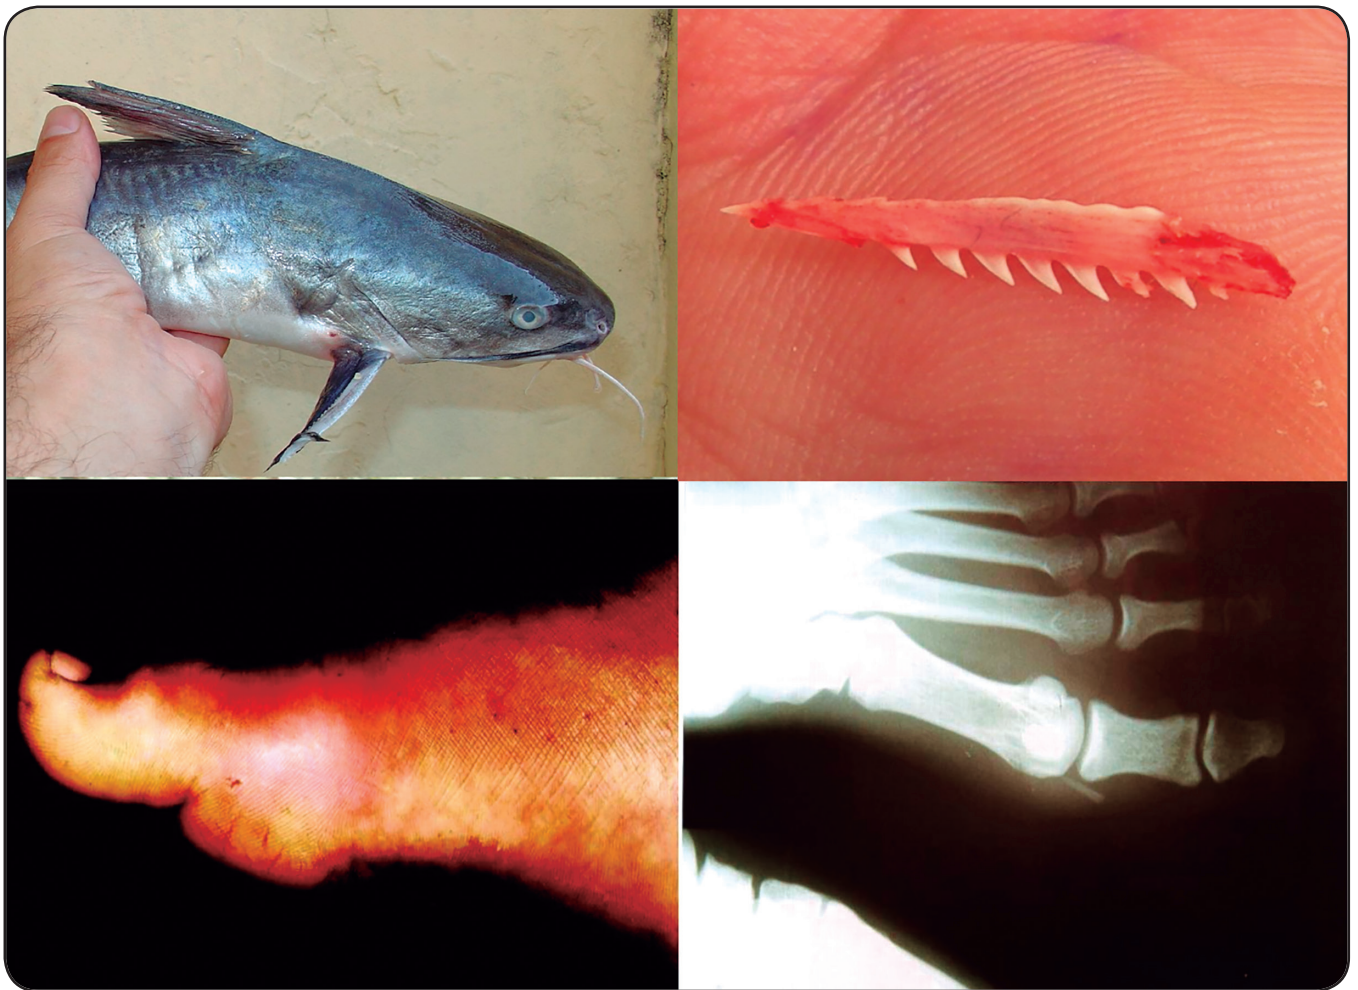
Marine catfish (Top left). Pectoral Sting in detail (Top right). Persisting inflammation three days after an injury caused by a catfish (Bottom left). Conventional radiography of the injured left foot (Bottom right). Increased radiographic density is seen around the first metatarsophalangeal joint (soft-tissue swelling). Note the sharp radiopaque structure near the first metatarsal head (fragment of the stinger).
